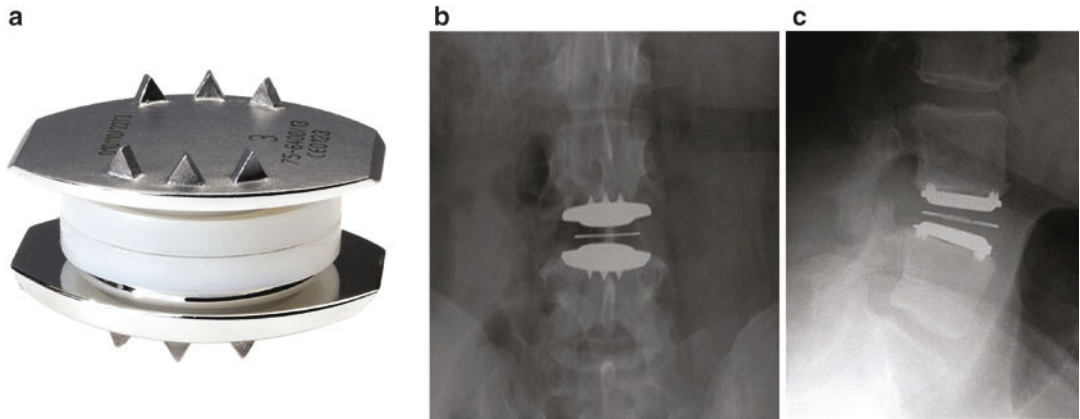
(a) The Charite artificial disc. (b) Anteroposterior radiograph of Charite disc placed at L4-L5. (c) Postoperative lateral radiograph at L4-L5 of Charite artificial disc
